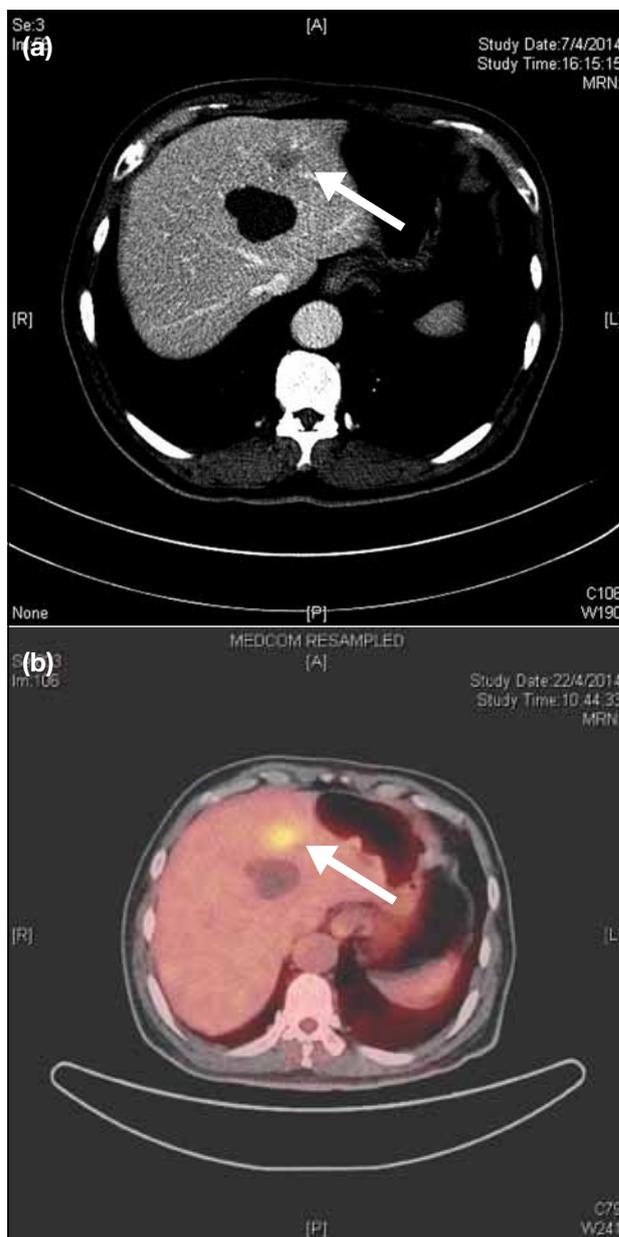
(a) Computed tomography and (b) positron emission tomography images of the patient show a hypermetabolic liver lesion at segments II and III (arrows).
